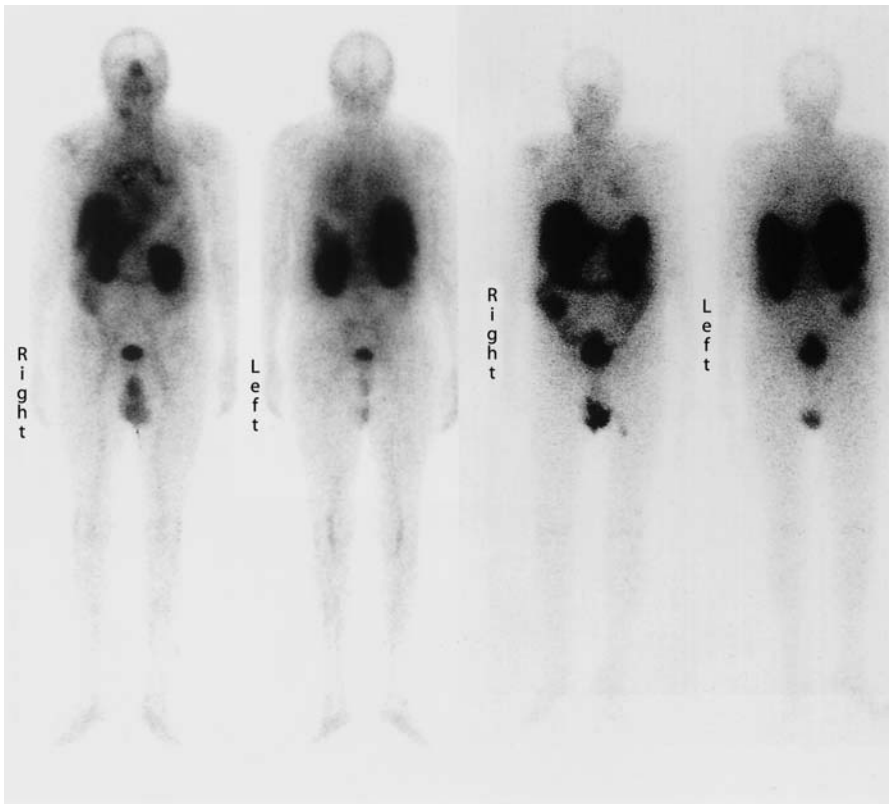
Bilateral mediastinal lymph node involvement (“chimney sign”) in a patient with the primary tumor in situ in the upper parts of the right lobe of the thyroid [*left panel*: anti-CEA immunoscintigraphy with ^{99m}Tc -labeled Fab’ fragments, clone NP-4 (CEAScan); *right panel*: ^{111}In -DTPA-octreotide somatostatin receptor scintigraphy; both scans at 24 h p.i.]
